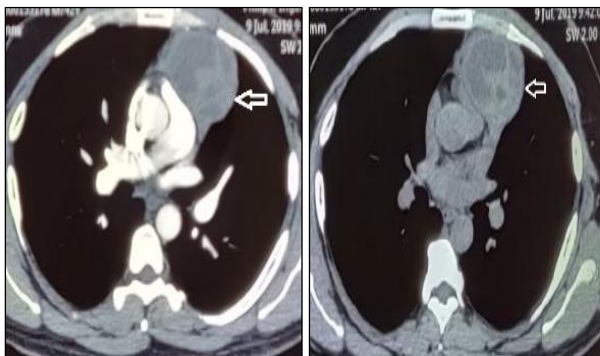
The chest computed tomography showed a large anterior mediastinal cystic mass lateralized to the left side likely to be cystic thymoma or a cystic teratoma (arrow).
